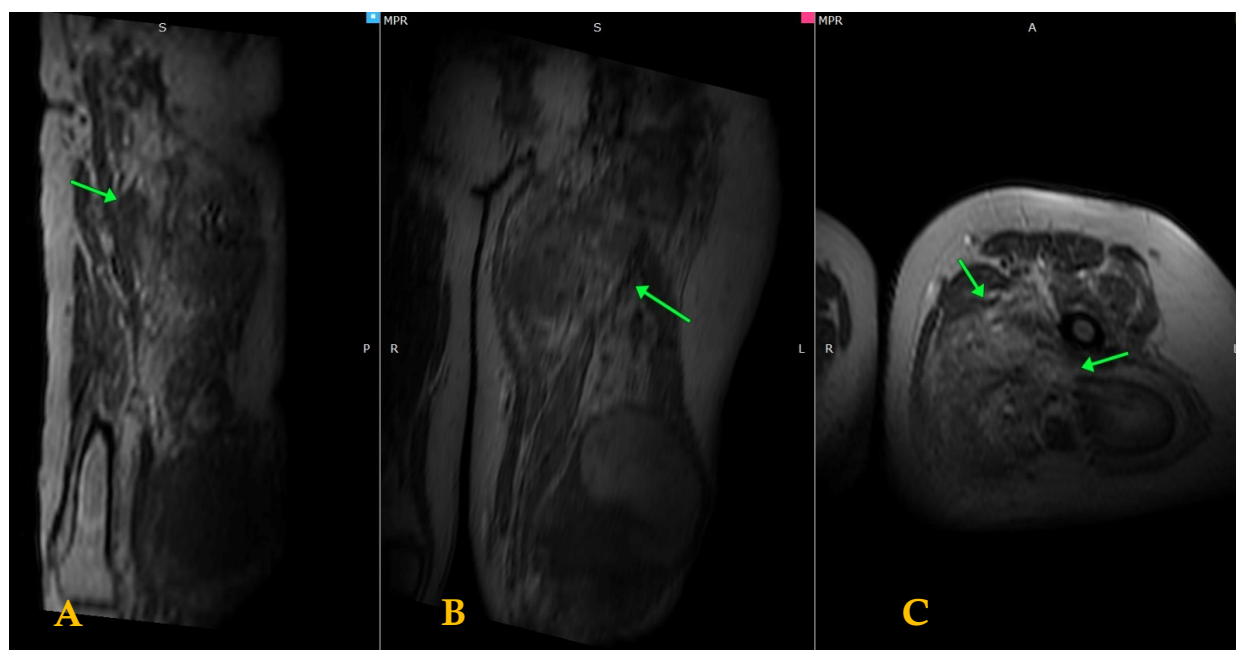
Contrast-enhanced MRI (T1WI) demonstrating multiple enhancing lesions in the left thigh infiltrating the adductor magnus, adductor longus, adductor brevis, and gracilis muscles (panels A–C).
